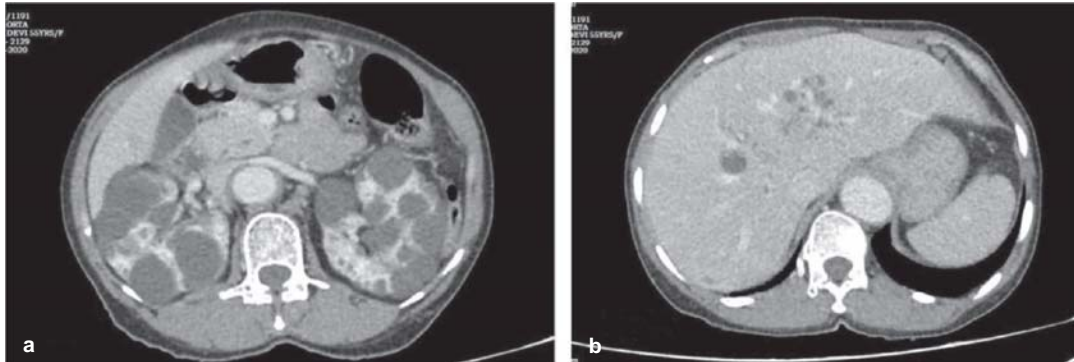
Axial portal phase computed tomography images showing (a) multiple variable-sized cysts in both kidneys, and (b) a few simple cysts in the liver
